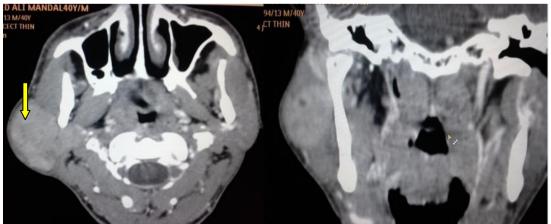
Malignant neoplasm of right parotid gland. Contrast CT of neck bulky right parotid showing heterogeneous enhancing mass.
